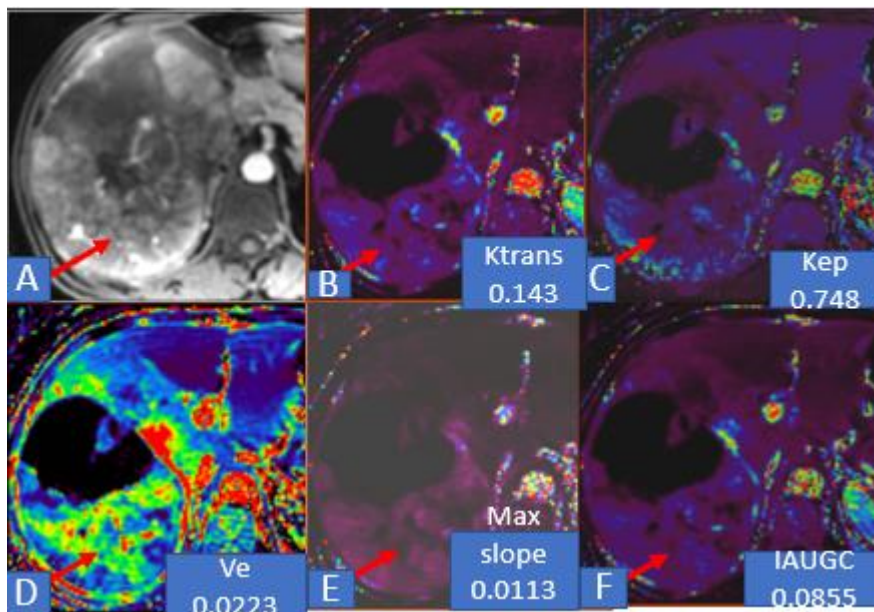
A. postTACE DCE MRI image showing a large HCC lesion with both necrotic and enhancing areas. In enhancing portion, mixed areas with enhancement and without enhancement noted. B-F colour maps of MR perfusion parameters showing decrease after TACE indicating false negative response.
